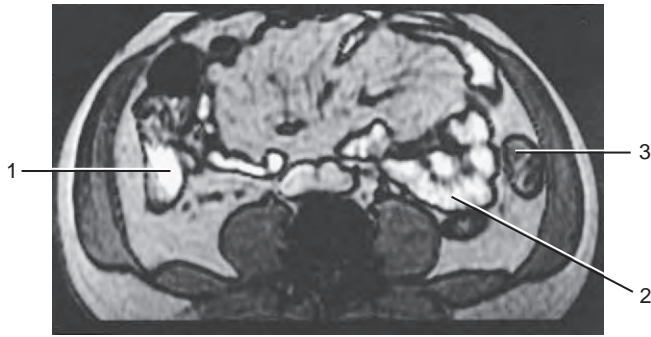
Axial section of MRI: ascending colon (1), small bowel (2), and descending colon (3).
